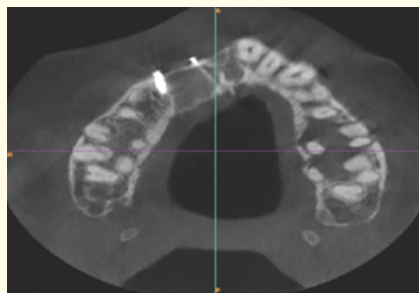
X-ray, the craft in its place.
